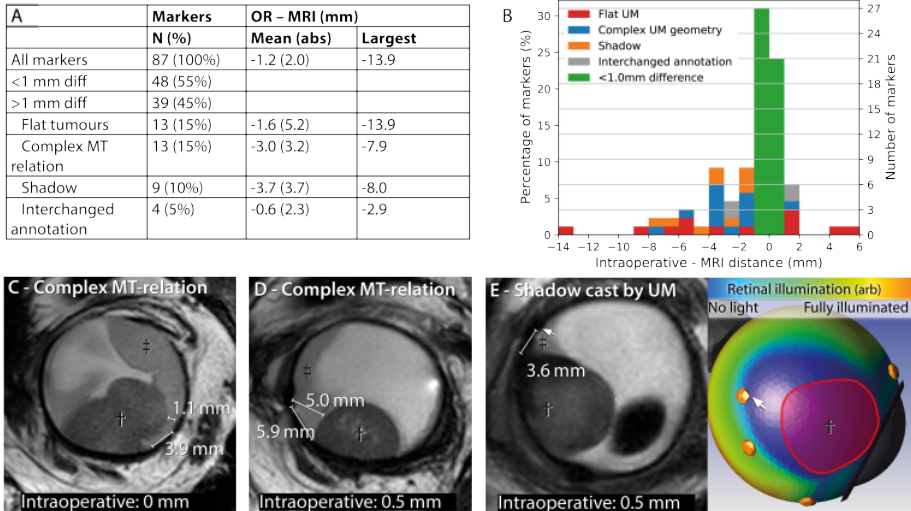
Intraoperative marker-tumor distances measurement compared with MRI based measurements. A negative value means that the MRI distance was larger than the interoperative measurement. (A,B) In 55% of the markers a difference of less than 1 mm was observed (green). The largest differences, up to 14 mm, were observed in flat melanoma (red). For 25% markers the difference was attributed to a complex tumor geometry (blue) or shadow cast by the tumor (orange). (C,D) For tumors with a complex marker-tumor relation one length might not be sufficient to describe the marker tumor relation. (E) For anterior located tumors the distance between posterior markers and tumor can be underestimated interoperatively due to a shadow that is cast by the tumor
